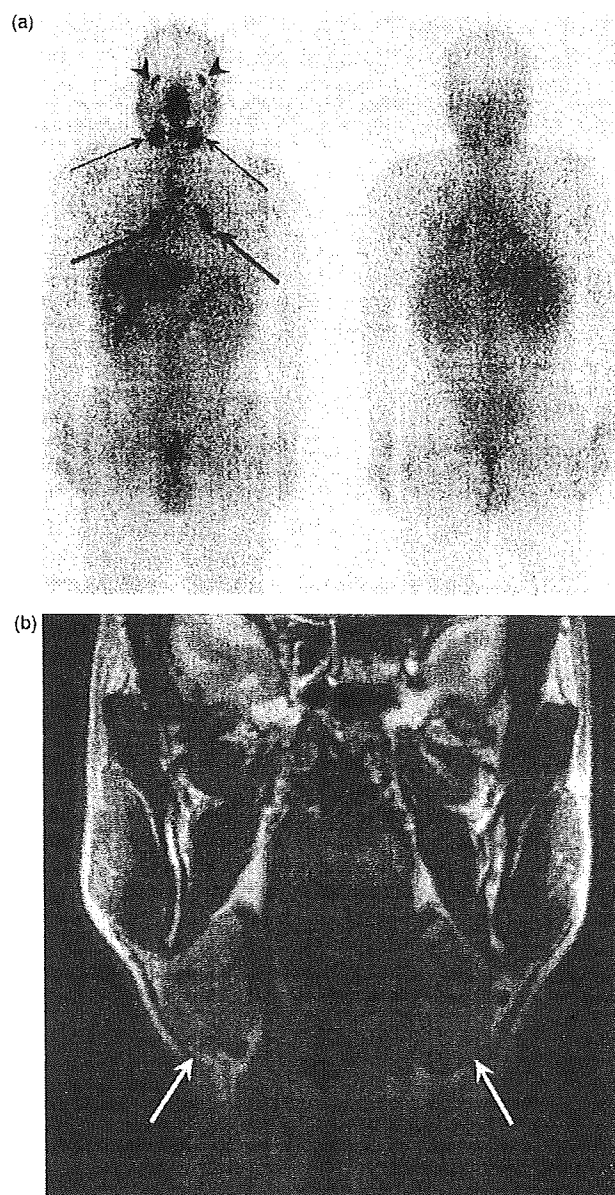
Lacrimal and salivary lesions in a 67-year-old man visualized with Ga-67 scintigraphy and MRI. (a) Ga-67 scintigraphy shows increased uptake in the hilar (arrows), submandibular (thin arrows), and lacrimal glands (arrow heads). (b) Coronal T2-weighted images show bilateral submandibular gland swellings that are homogeneous without dilatation of the ducts (white arrows).
